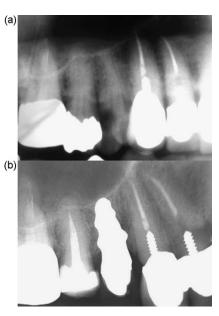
(a) X-ray before extraction. (b) X-ray at 1-year follow up with the zirconium implant and crown *in situ*.
